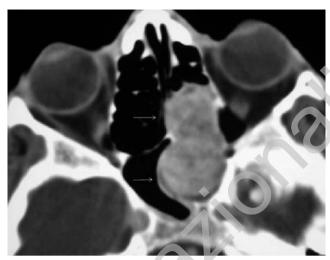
Contrast-enhanced axial CT image shows a bulging enhancing tumor (white arrows) arising from the left ethmoid sinus.
